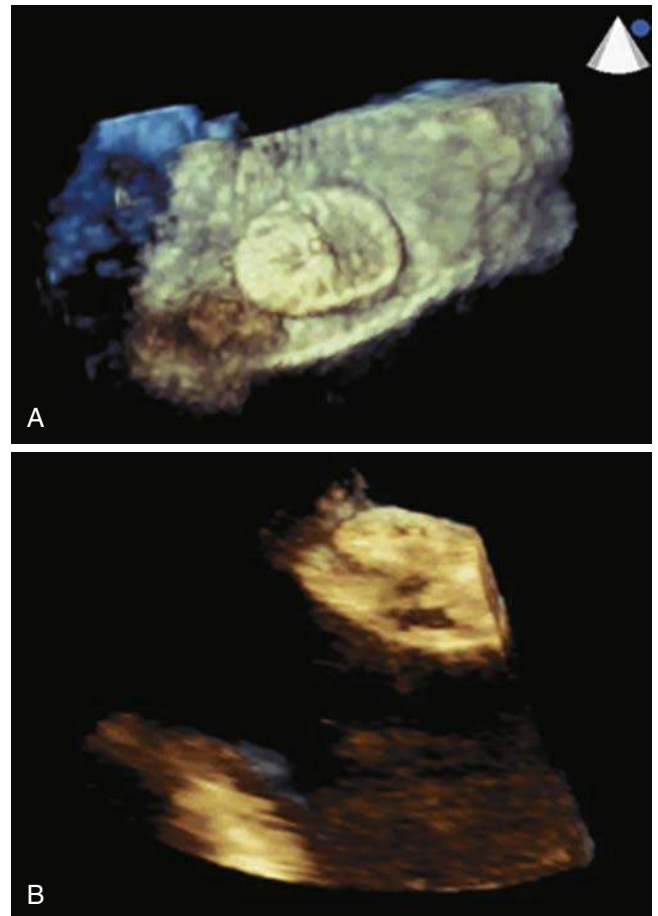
Three-dimensional transesophageal echocardiogram from a patient in whom an Amplatzer occluder was used to close a patent foramen ovale. Two orthogonal views of Amplatzer occluder: view from the left atrium (A) and side view (B). (Courtesy Wei Li, MD, PhD, Royal Brompton Hospital and the National Heart & Lung Institute, Imperial College, London, United Kingdom.)
